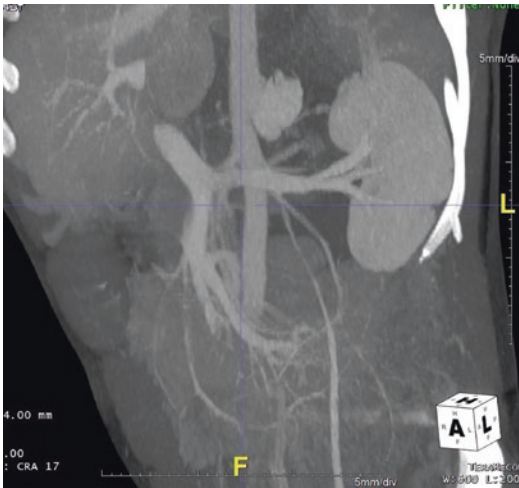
Computed tomographic reconstruction of a gunshot wound to the abdominal aorta. Proximal vascular occlusion balloon was utilized to control the injury prior to open repair
